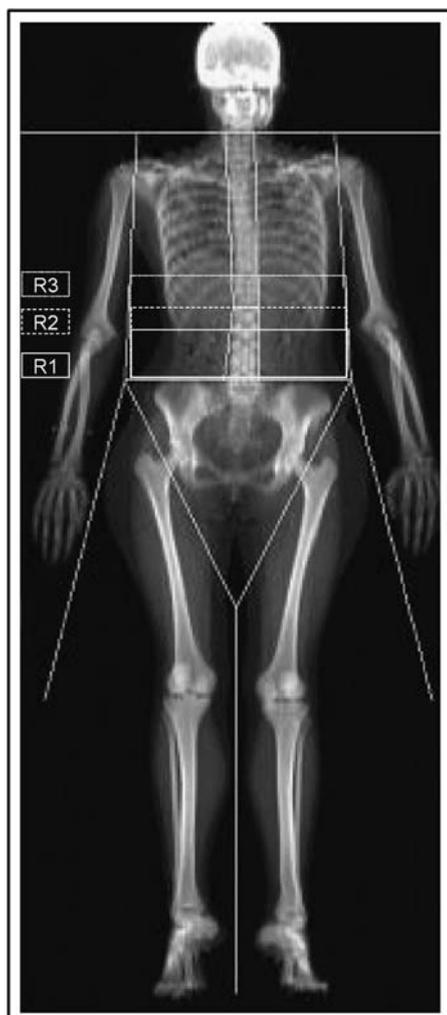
Abdominal fat regions by Dual-Energy X-ray Absorptiometry.
